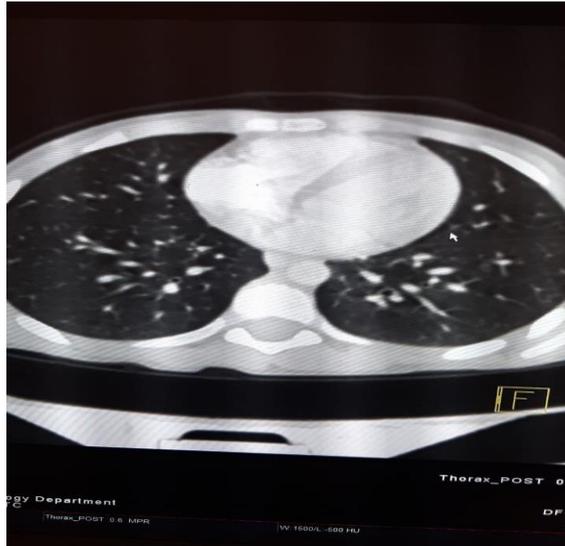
CT CHEST showed no distant metastasis
